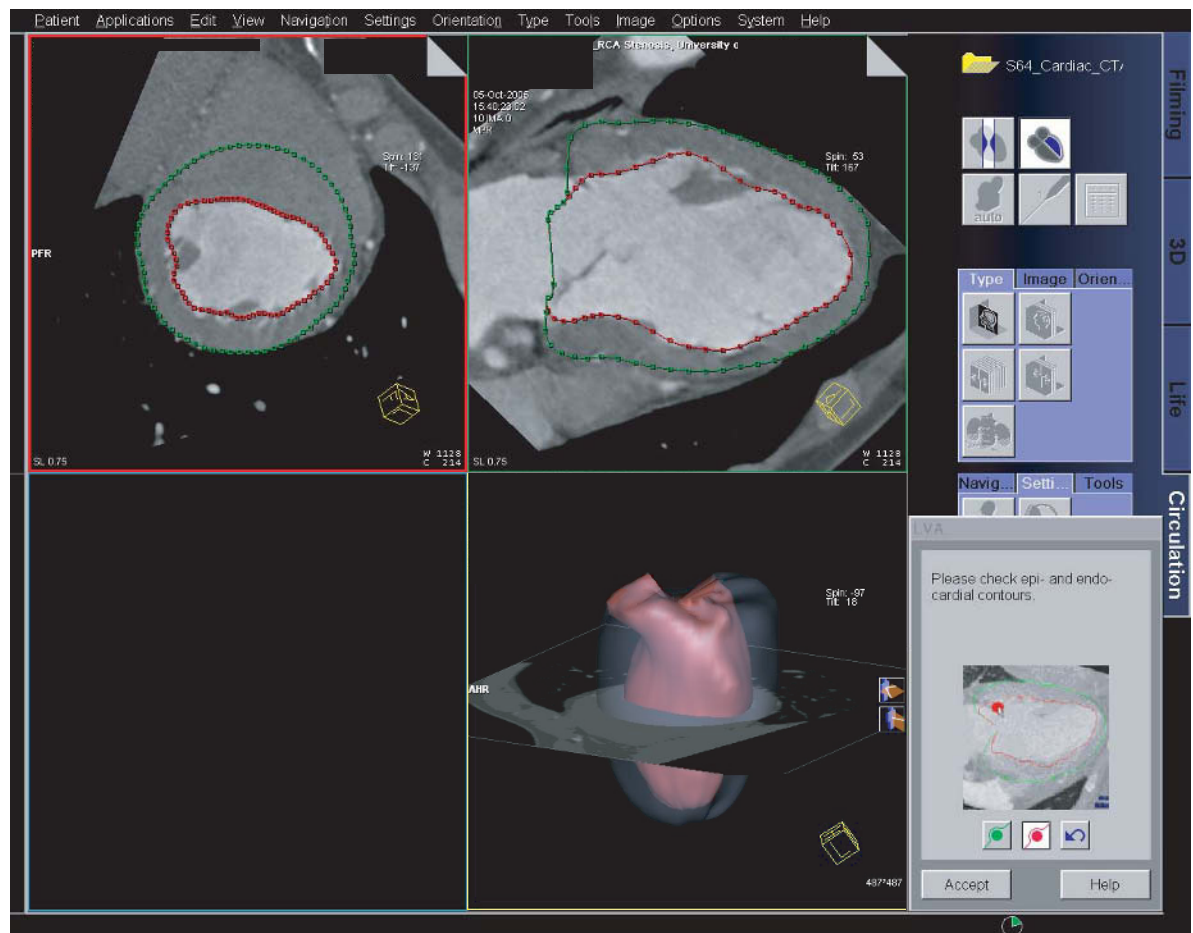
Cardiac CT angiography examination obtained using a 64-slice CT scanner with 0.6-mm collimation and 0.33-s rotation time. Image data were reconstructed during end-diastole at 80% of the RR-interval. Automated volumetric segmentation and modeling of the left ventricular volume provide accurate input for the assessment of global cardiac function. (Case study courtesy of the University of Erlangen, Germany)
